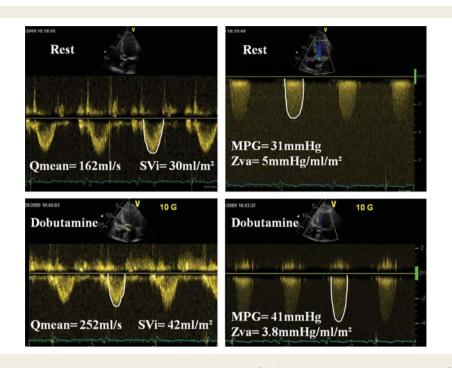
Figure I Doppler echocardiographic measurements in a patient with low-flow/low-gradient severe aortic stenosis. Resting indexed aortic valve area was $0.35 \text{ cm}^2/\text{m}^2$ and increased up to $0.5 \text{ cm}^2/\text{m}^2$ under $10\mu\text{m/kg/min}$ of dobutamine infusion. Systolic arterial pressure remained unchanged during the test. The normalization of transvalvular flow rate (Qmean) during dobutamine stress echocardiography resulted in a significant decrease in valvuloarterial impedance (Zva). SVi indicates indexed stroke volume and MPG, mean pressure gradient.
